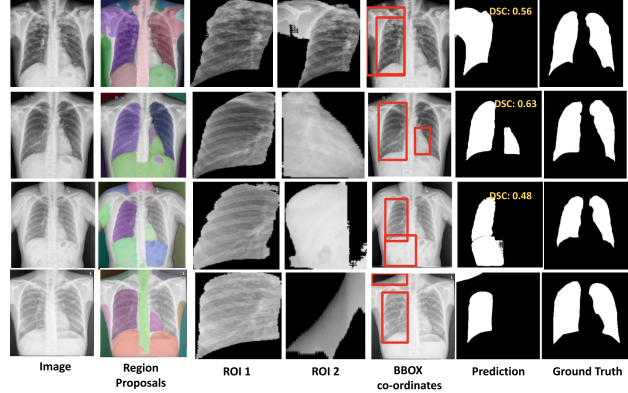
Visualization of failure cases on X-ray labels and masks dataset [19]. First two rows: SAM generates masks for both the left and right lung, but CLIP retrieves only the right lung mask correctly. While rows three and four show cases where SAM does not generate a mask for the left lung, eventually CLIP does not recognize the correct crop for the left lung in such cases.
